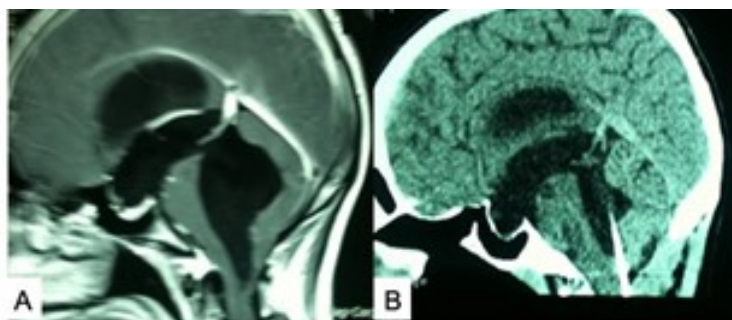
(A) MRI shows entrapped and dilated 4th ventricle. (B) MRI shows previous entrapped and dilated 4th ventricle treated using a 4th ventricular shunt. Source: Figure by authors.
